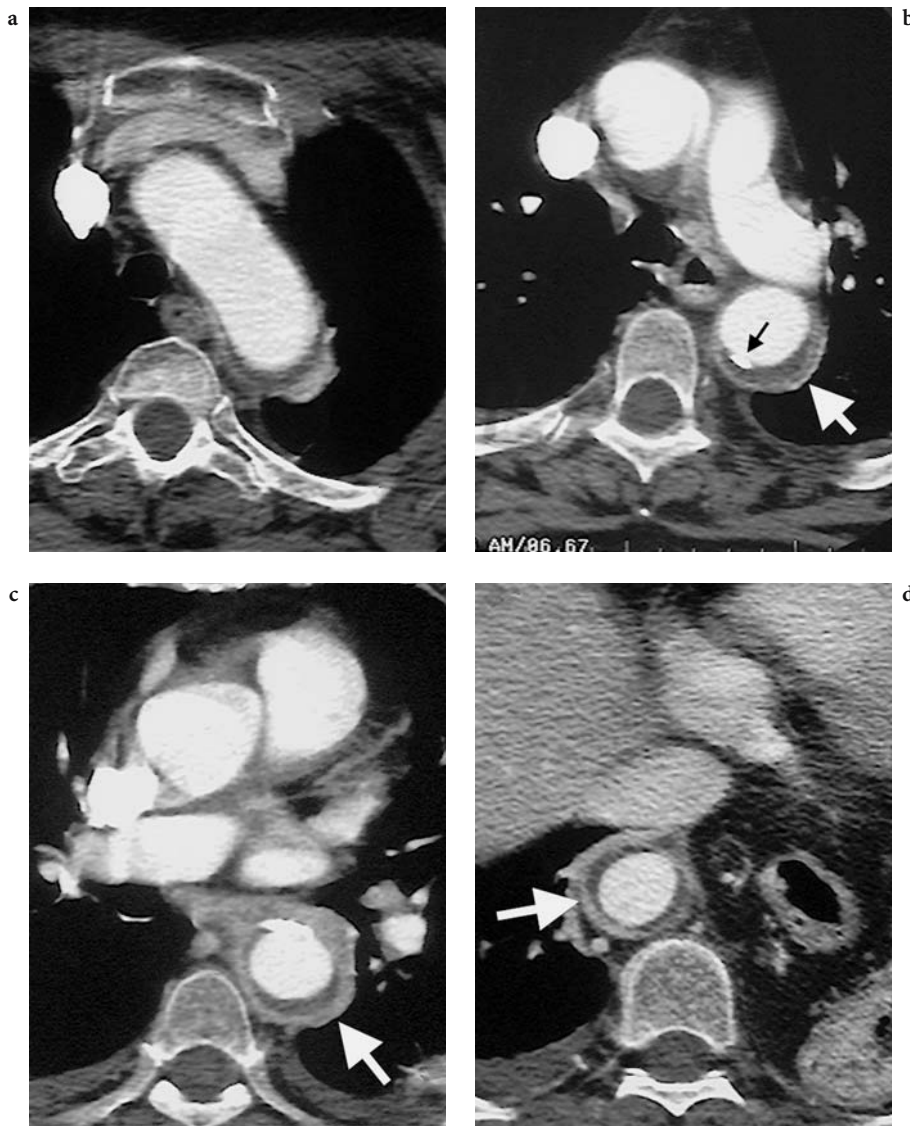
Transverse CTA sections demonstrate a descending thoracic aortic intramural hematoma associated with marked aortic wall enhancement and thickening (*white arrow*). The subintimal location of the hematoma is confirmed by the presence of intimal calcium on its internal surface (*black arrow*). Ulceration was not identified
